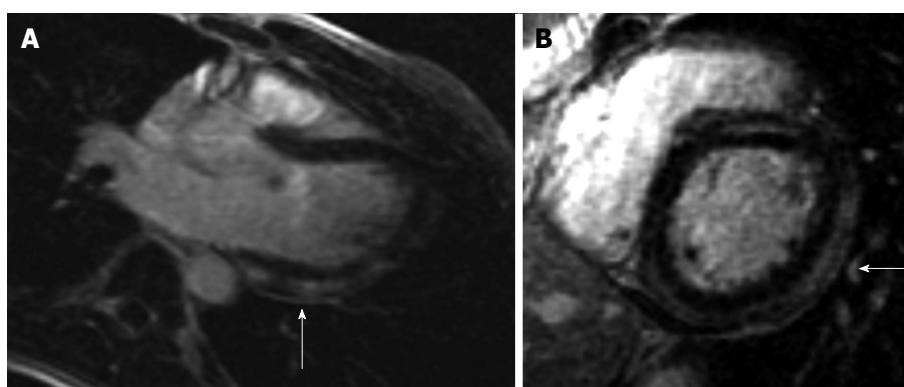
Cardiac magnetic resonance imaging findings. Cardiac magnetic resonance demonstrates pathological delayed gadolinium enhancement (as indicated by arrows). A: Long axis view: Delayed enhancement of the myocardium demonstrates subepicardial and mid myocardial enhancement indicative of myocarditis; B: Short axis view: Delayed enhancement of the myocardium demonstrates subepicardial and mid myocardial enhancement indicative of myocarditis.
